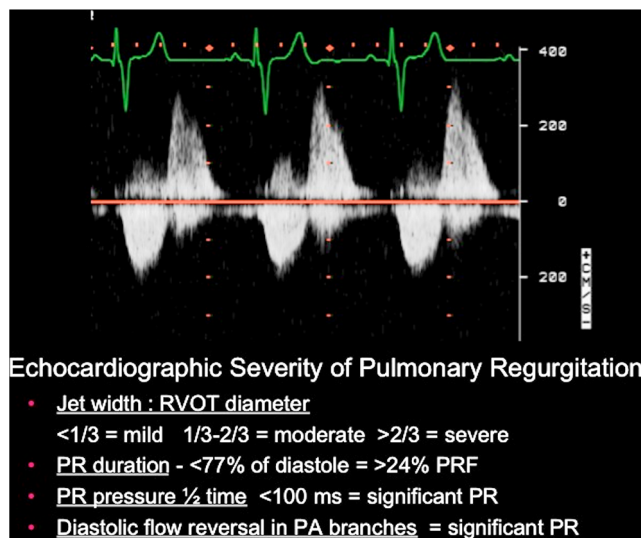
Continuous Wave Doppler profile from a patient with severe pulmonary regurgitation following repair of Tetralogy of Fallot. Several echocardiographic measures of the severity of pulmonary regurgitation are shown. PRF pulmonic regurgitation fraction
